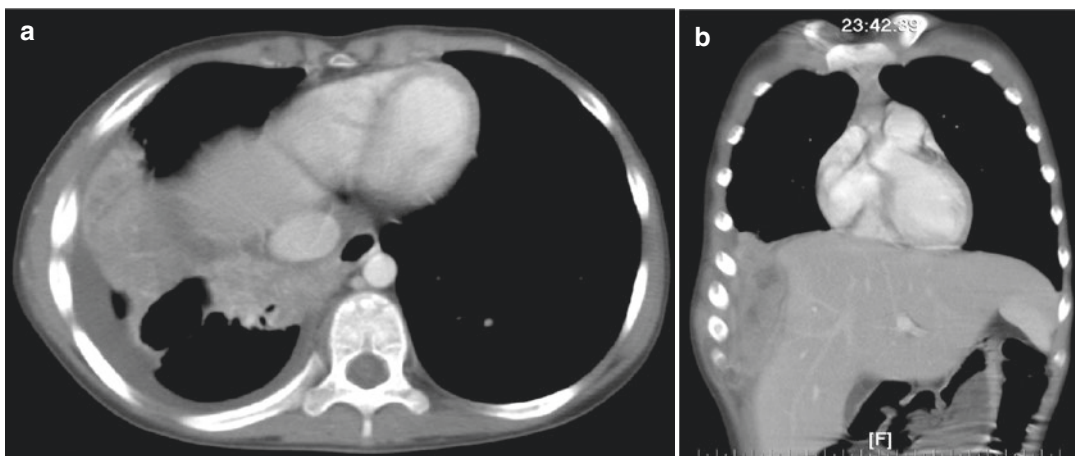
Chest CT at admission showed subphrenic abscess, pleural effusion, and a subcutaneous mass over right chest area in axial (a) and coronal (b) views
